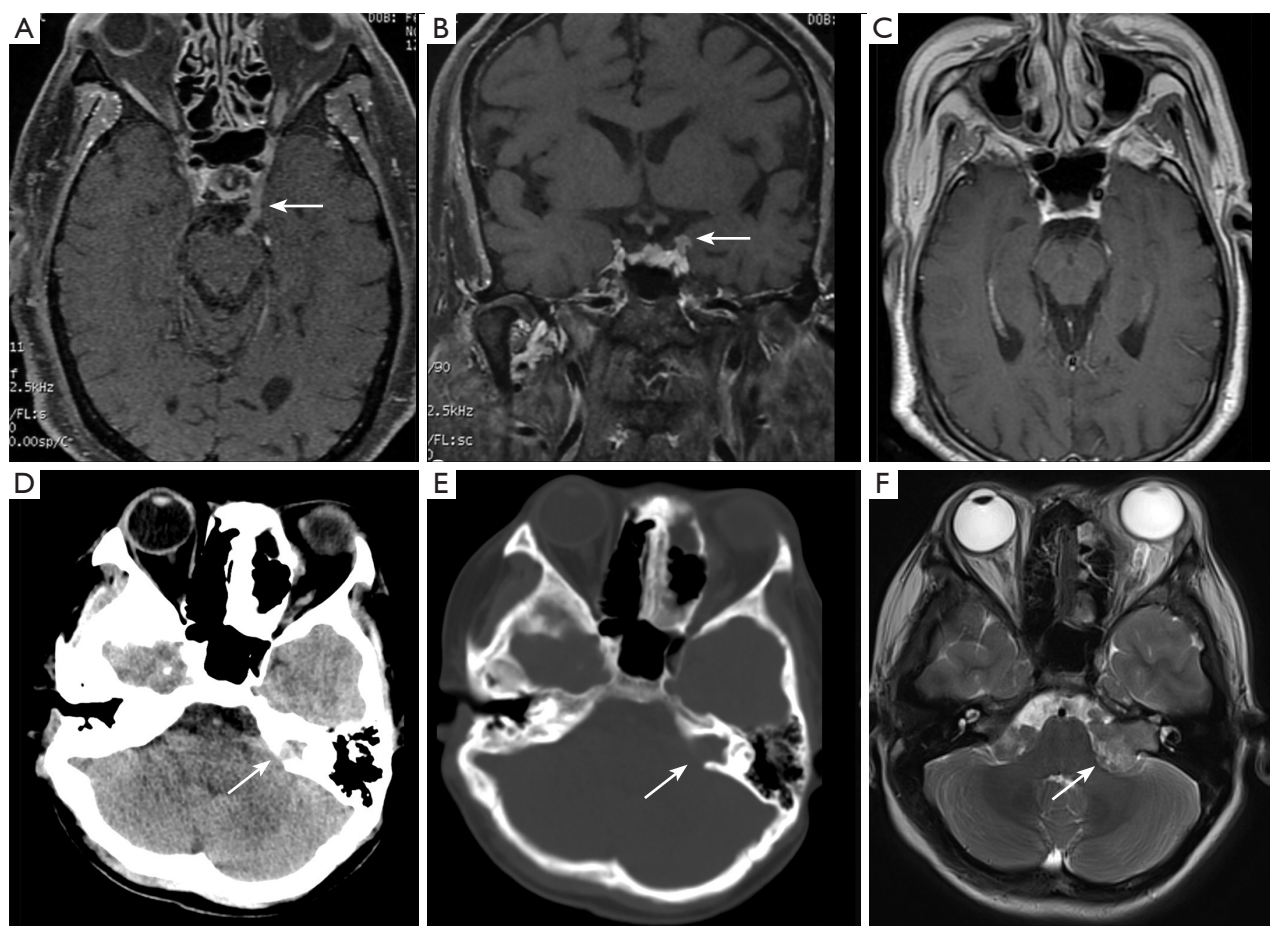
Blind spot in brain imaging: cranial nerves. (A-C) Scans of a 65-year-old male with lymphoma and ptosis of the left eye. (A,B) Axial and coronal enhanced MRI showed thickening and enhancement of the left oculomotor nerve (arrows). Taking into account the specific clinical presentations of this patient, a diagnosis of lymphoma affecting the oculomotor nerve was considered. (C) After chemotherapy, the previously thickened oculomotor nerve returned to normal. (D-F) Scans of a 20-year-old female after surgery for neurofibromatosis. (D,E) CT scan showed an enlargement of the left internal auditory canal (arrows), suggesting a pathological condition in the left internal auditory canal region. (F) MRI revealed multiple abnormal signal masses and nodules in the bilateral cerebellopontine angles, pons, and medulla oblongata. Among them, the largest lesion was located in the left cerebellopontine angle (arrow), extending along the facial nerve to the internal auditory canal, with localized canal enlargement. Ultimately, a diagnosis of multiple neurofibromas was made. MRI, magnetic resonance imaging; CT, computed tomography.
